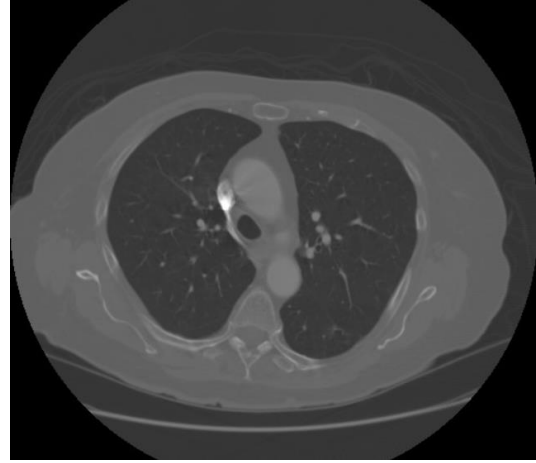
2D CT scan slice from a lung cancer patient with a malignant nodule
